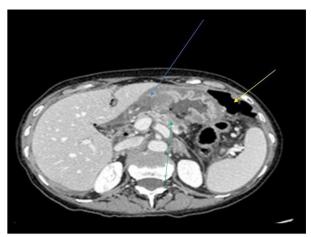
Axial image from an abdominal computed tomography (CT) scan in a 58-year-old Lebanese woman who presented with acute gastric perforation due to metastatic ductal carcinoma 18 years following bilateral mastectomy. The yellow arrow shows pneumoperitoneum. The green arrow shows tumor in the pancreas. The blue arrow shows an area of fluid associated with gastric perforation.
